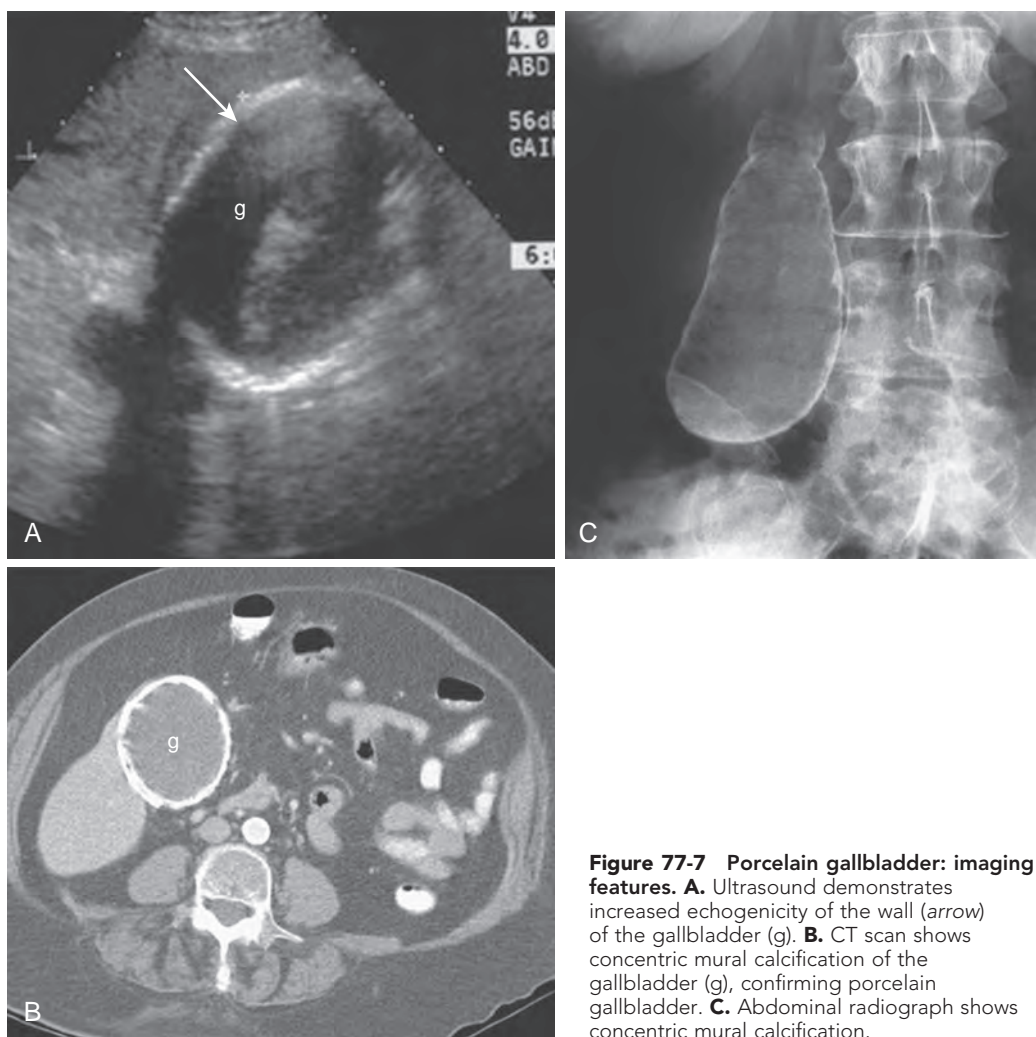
Porcelain gallbladder: imaging features. A. Ultrasound demonstrates increased echogenicity of the wall (arrow) of the gallbladder (g). B. CT scan shows concentric mural calcification of the gallbladder (g), confirming porcelain gallbladder. C. Abdominal radiograph shows concentric mural calcification.
